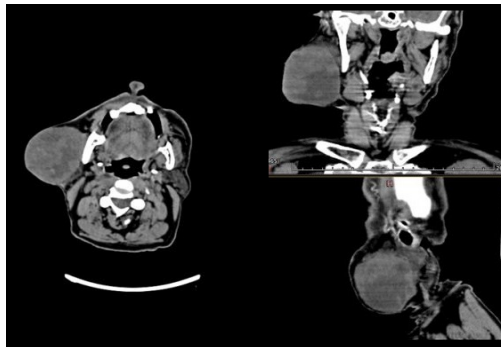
Contrast-enhanced CT scan demonstrating heterogeneous lesion in right parotid region
